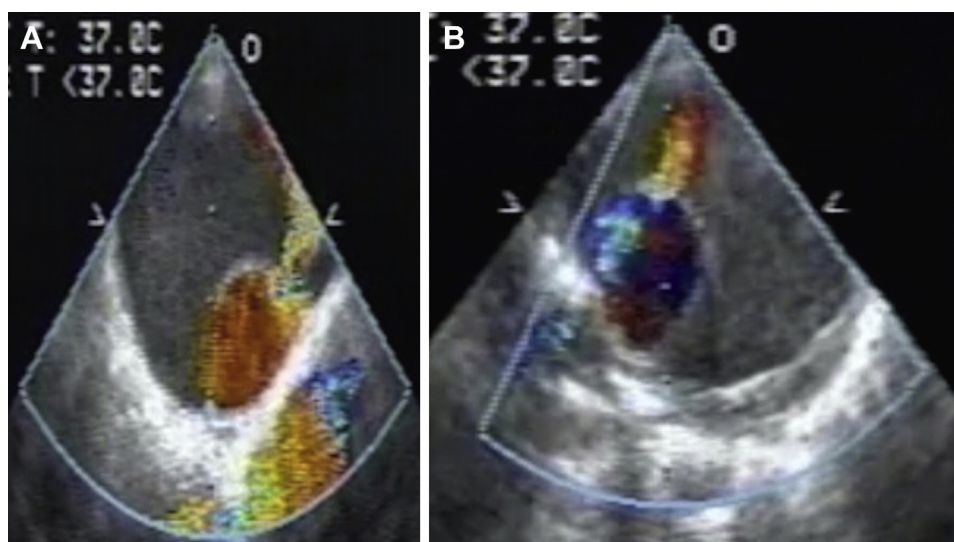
Presurgical transesophageal echocardiography. Both images show stagnant vascular flow of false lumen. A, Vascular flow from true lumen to false lumen at T8 spinal level. B, Vascular flow from true lumen to false lumen at celiac artery level.
